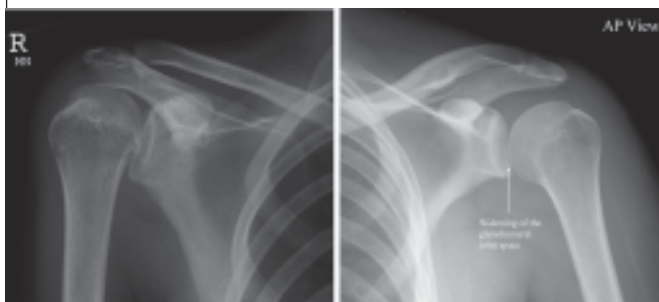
Radiograph showing posterior dislocation of shoulder
